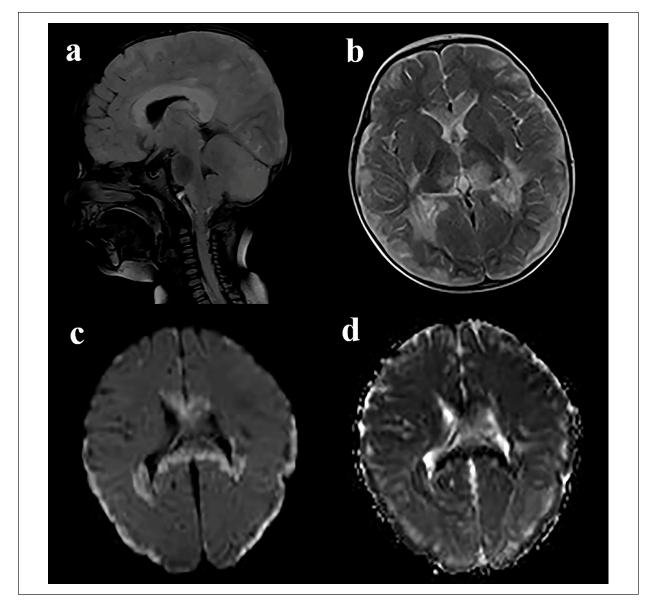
Magnetic resonance imaging of the reported patient with acute progressive encephalitis associated with coronavirus disease 2019. Abnormal T2/fluid-attenuated inversion-recovery hyperintense lesions are noted in the entire corpus callosum, ventral aspect of medulla oblongata, and cerebellar vermis (a). Hyperintense lesions on axial T2-weighted image are noted in bilateral thalami, corpus callosum, bilateral peritrigonal white matter, and cerebral cortex (b). Restricted diffusion in the corpus callosum and periventricular white matter, as well as bilateral subdural effusion, are seen on diffusion-weighted imaging (c), and apparent diffusion coefficient mapping (d).
